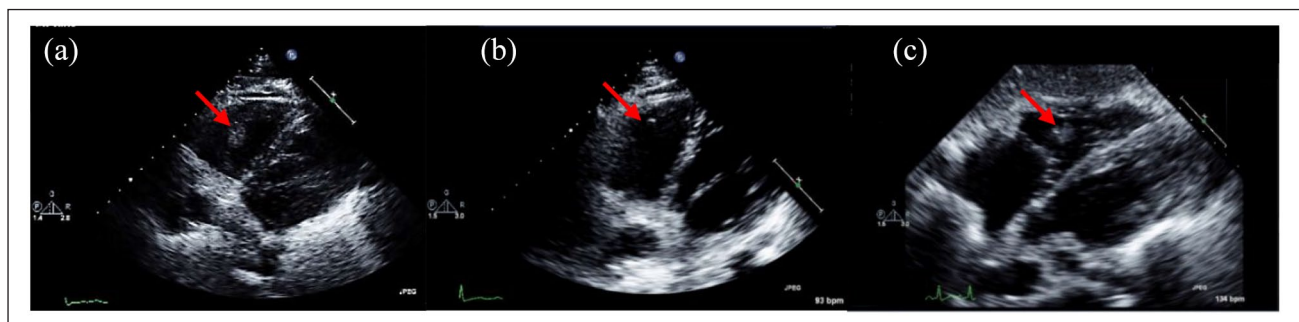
(a) Transthoracic echocardiogram showing a dilated right ventricle with a mobile echodensity suggestive of thrombus (Day 11). (b) Similar echocardiographic view after two tPA treatments (Day 14). (c) Echocardiographic showing recurrence of the RV thrombus (Day 21). In this occasion, a globular RV thrombus in transit “caught” in the tricuspid chordae was observed.
